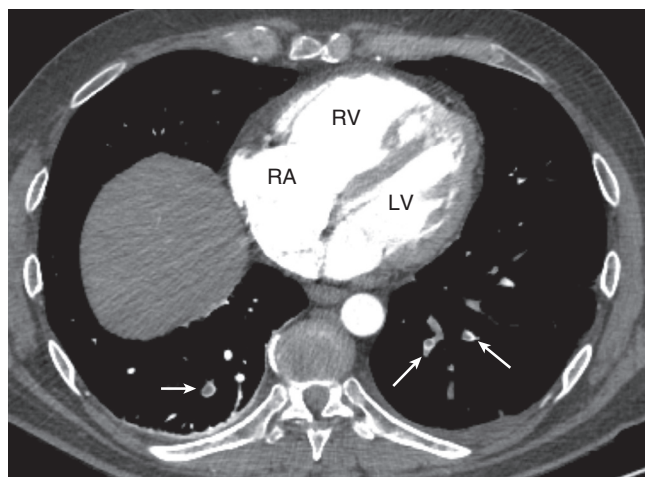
■ Pulmonary embolism and right ventricular strain. Contrast-enhanced axial multidetector computed tomography shows multiple filling defects in the segmental pulmonary arteries of the lower lobes (arrows). Note dilation of the right ventricle (RV) and right atrium (RA). The right ventricle is larger than the left ventricle (LV), and there is straightening of the interventricular septum. These findings are consistent with right heart strain.
